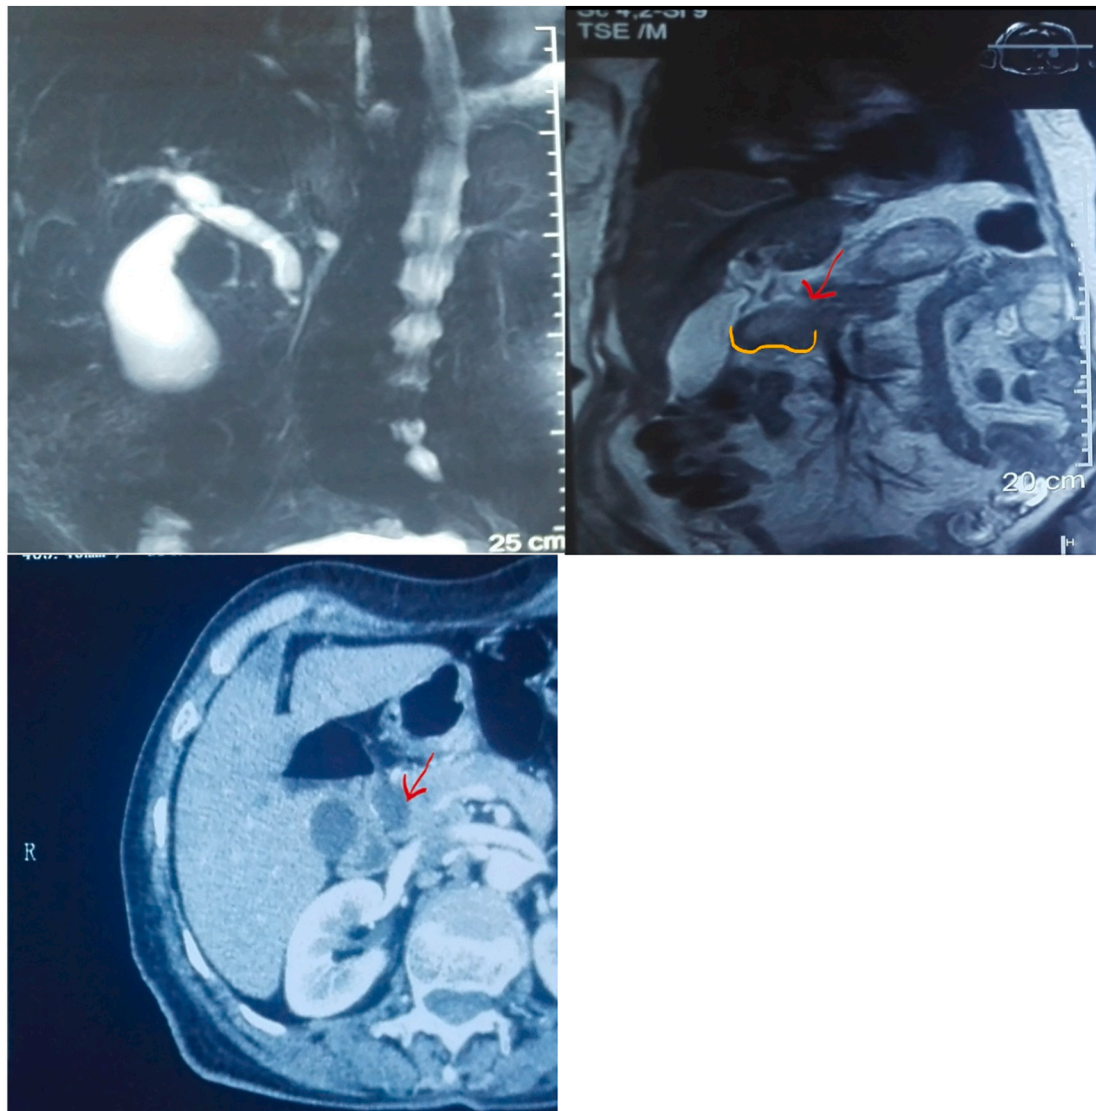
A: MRCP: Choledocus dilation without calculus. B: MRCP: Diverticulum at the middle duodenal wall C. Computed axial tomography scan (CT): duodenal section.
